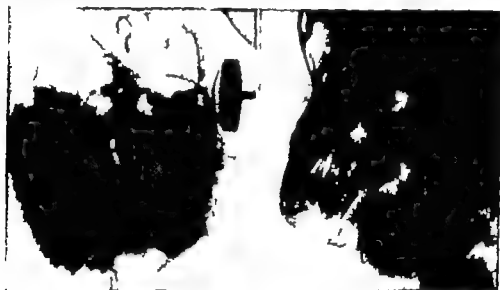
Roentgenograms of osteosarcoma of the jaw (Left) Sclerosing osteogenic sarcoma of the upper jaw (Memorial Hospital, New York) (Right) Osteogenic sarcoma of the lower jaw producing a mottled area of bone destruction, followed by pathologic fracture.
